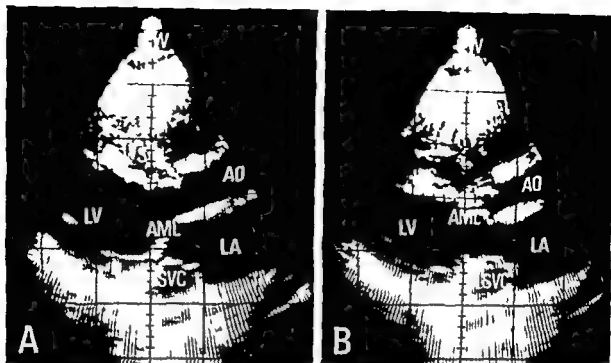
Cross sectional echocardiograms of a long cardiac axis in a 24 year old female patient having PLSVC with ASD. Panel A is an image of systole and panel B is recorded in early diastole. An unusual circular echo is recognized at the boundary between the left atrium and the left ventricle. Its circular echo shows an almost complete round form. Abbreviations: CW = chest wall, RV = right ventricle, IVS = interventricular septum, AO = aorta, LA = left atrium, LV = left ventricle, AML = anterior mitral leaflet, SVC = left superior vena cava.
